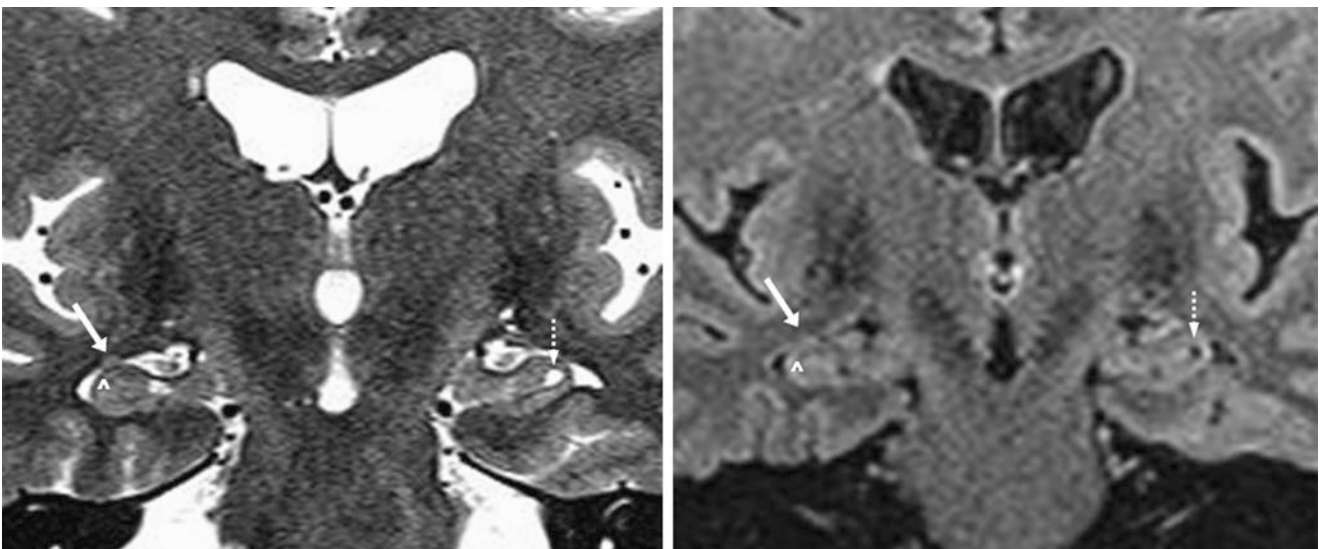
A 54 year old with seizures; on a negative 3 T MRI, coronal T2WI (*left*) depicts the right caudate tail (*arrows*), which is not well visualized on coronal FLAIR (*right*). Note the hippocampus/CA2
